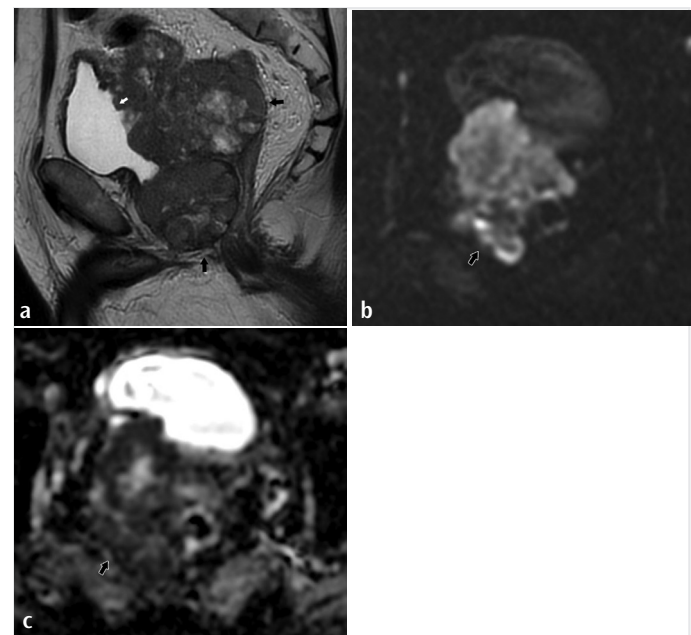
Giant prostate adenocarcinoma (black arrow) with invasion of rectum (black arrow) and bladder (white arrow) on sagittal T2-weighted sequence.
